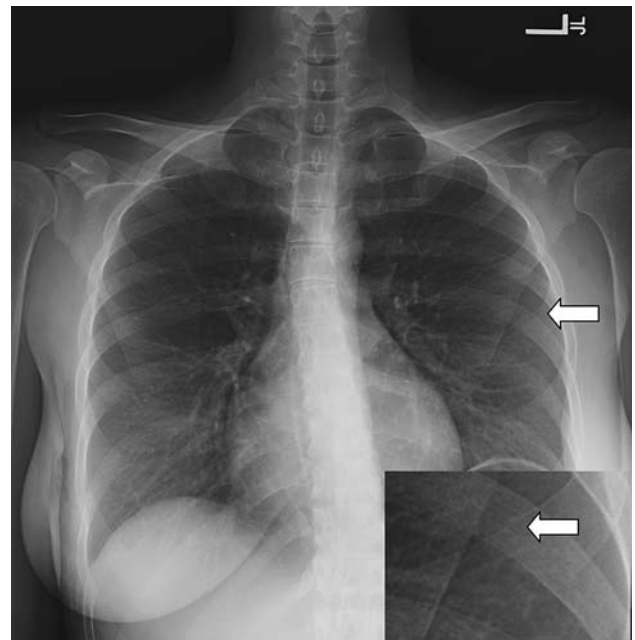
A chest radiograph shows osteopenia throughout. The inset and arrow note a minimally displaced cortical disruption of the left fourth rib.
